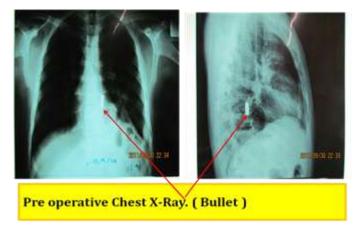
Figure \: Preoperative Chest X-Ray.
